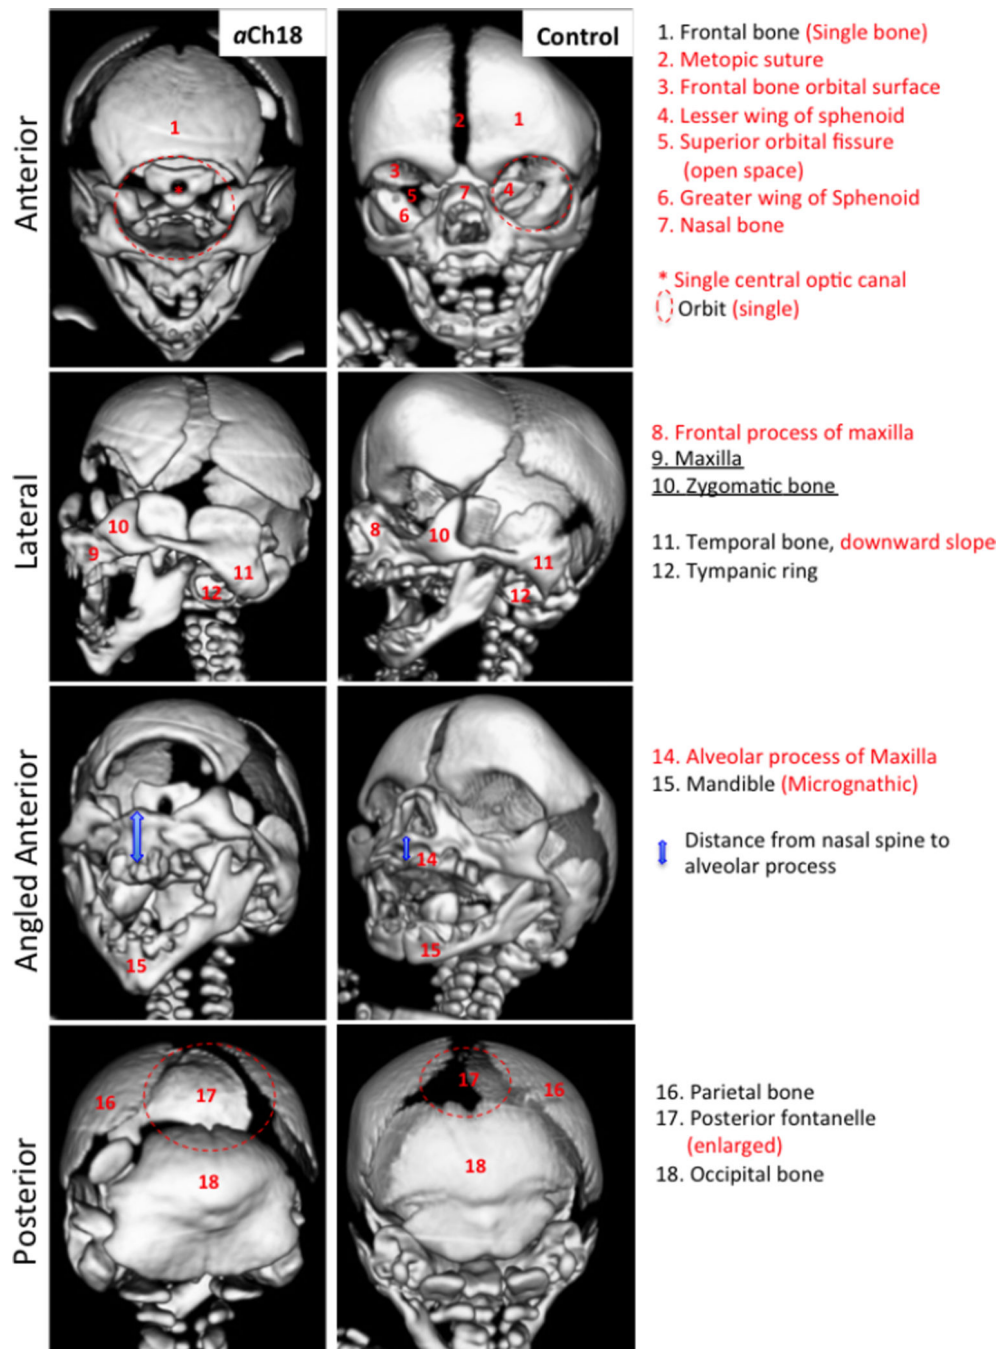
Craniofacial features of bone in aberrant Ch18 (*aCh18*) fetus compared with control. 3D reconstructed CT scans of a 28-week old *aCh18* (left column) vs. a 29-week control fetus. Anterior (1st row), lateral (2nd row), angled anterior (3rd row) and posterior (4th row) perspectives of the cranium. Lateral features are preserved, whereas medial structures are severely impacted. Red lettering indicates an absence or abnormality in *aCh18*.
